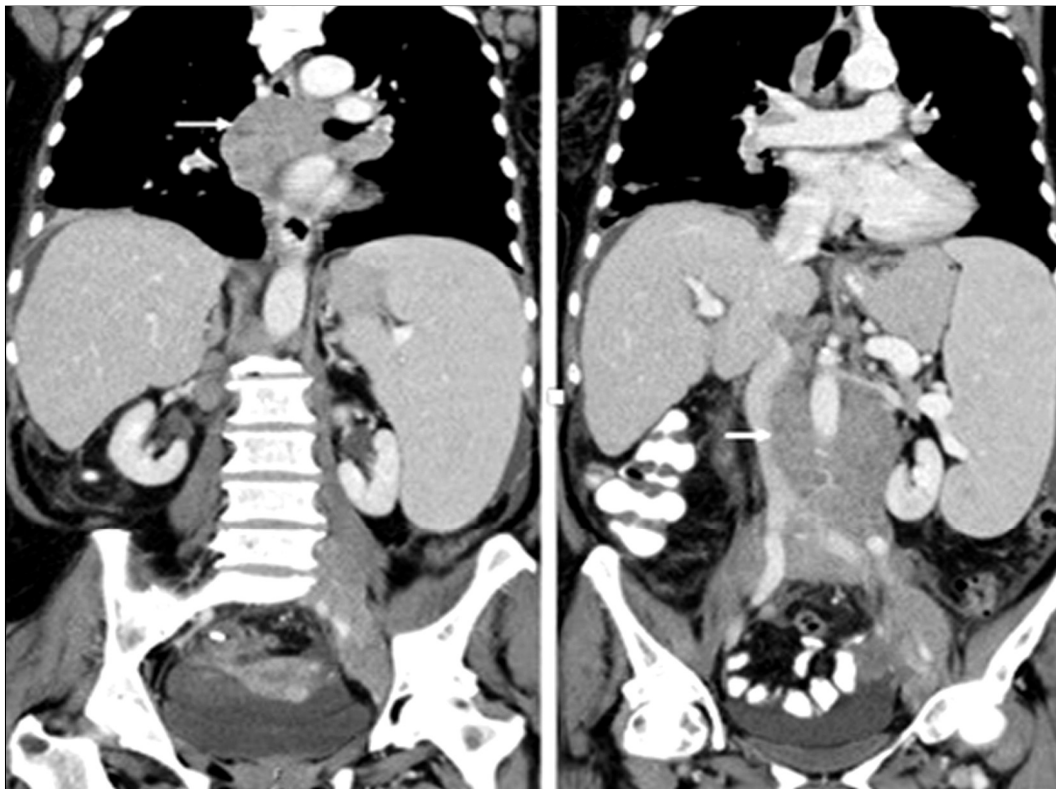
Thoraco-abdominal CT scan with contrast enhancement showing multiple enlarged lymph nodes in the mediastinum and retroperitoneum along the inferior vena cava and abdominal aorta (white arrows).
